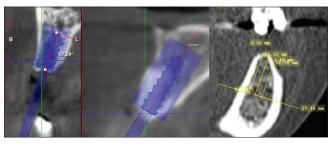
Implant angulation planning in cone beam computed tomography and computed tomography
